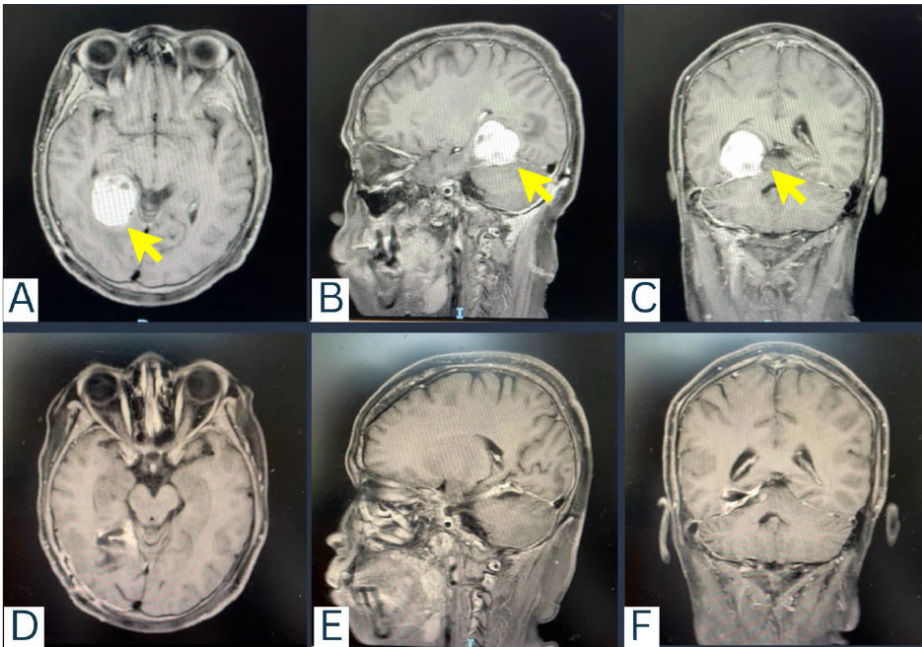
A. Axial, B. Sagittal and C. Coronal view T1W sequence of magnetic resonance imaging with contrast showed enhancement of tumor in the right intraventricular trigone (yellow arrow). (D,E,F) 2 weeks after tumor removal.
